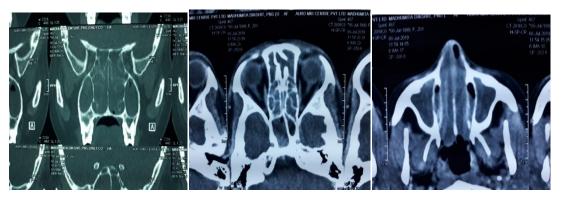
(a, b, c): Chronic rhinosinusitis and sinonasal polyposis diagnosed in CT
